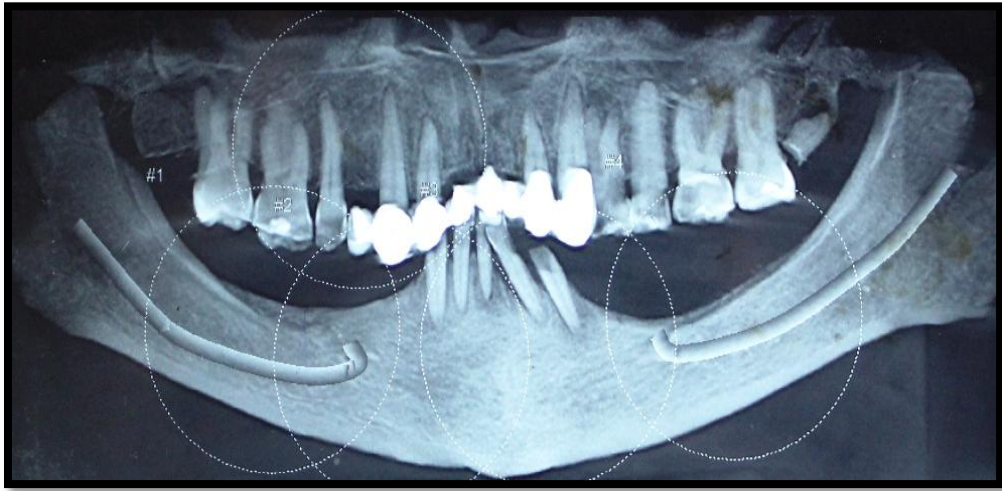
Pre operative CBCT image
